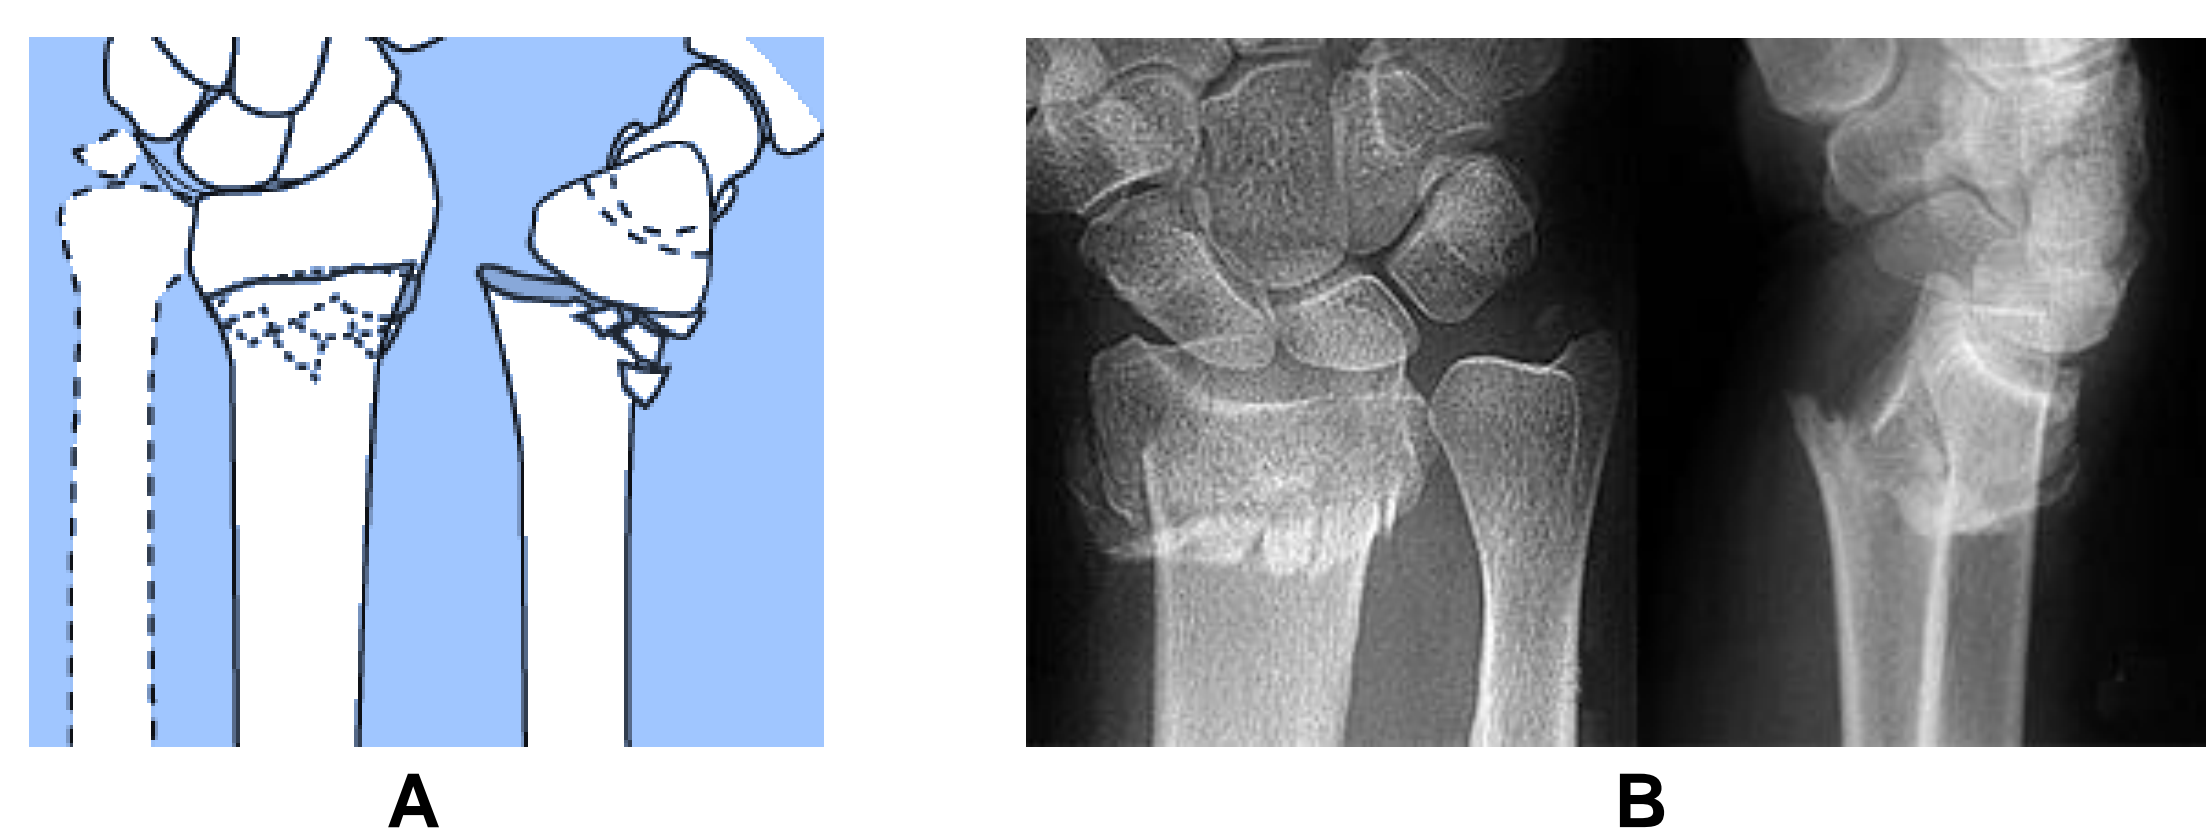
A. Extra-articular multi-fragmentary fracture of the distal radius with angulated dorsal wedge fragment (AO 23-A3.2). B. Radiographic depictions of AO 23-A3.2 fracture.
